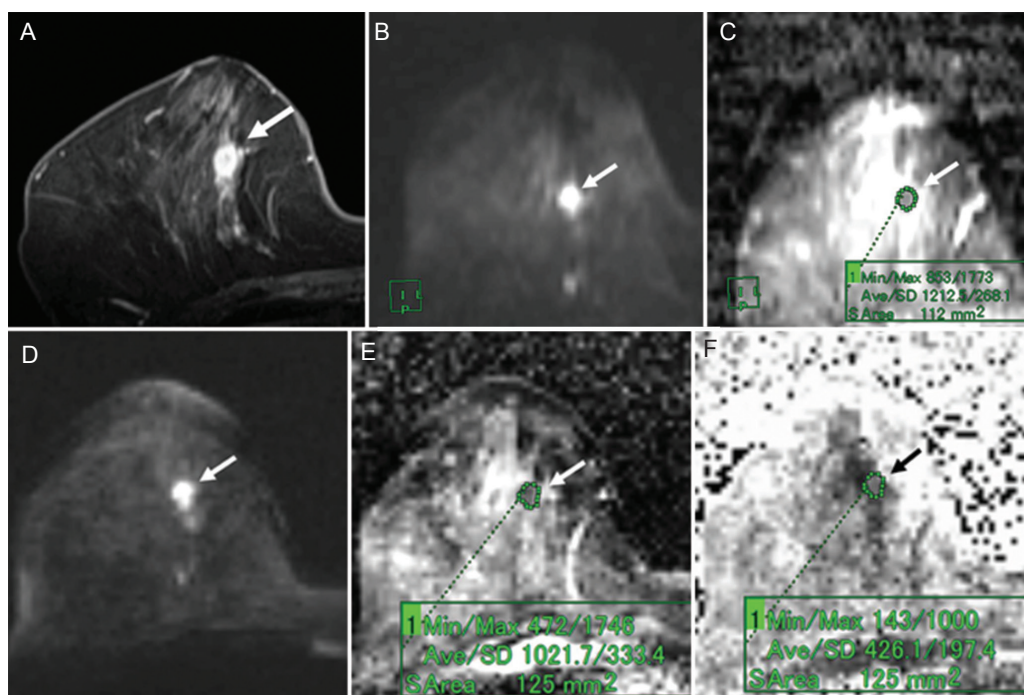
A 66-year-old woman with invasive ductal carcinoma (luminal A-like type). (A) Post-contrast, fat-suppressed, axial T₁-weighted image. (B) DWI based on ss-EPI. (C) ADC map of panel B. (D) DTI based on rs-EPI. (E) ADC map of panel D. (F) FA map of panel D. Post-contrast, fat-suppressed, axial T₁-weighted image shows an oval-shaped mass with a slightly irregular margin and rim enhancement (A). The mass shows high signal intensity on both the DWI based on ss-EPI (B) and the DTI based on rs-EPI (D). On the ADC map of the DWI image, the ADC of the mass was 1.21 (C). On the ADC map of the DTI image, the ADC of the mass was 1.02 (E). On the FA map, the FA value of the mass was 0.43 (F).
